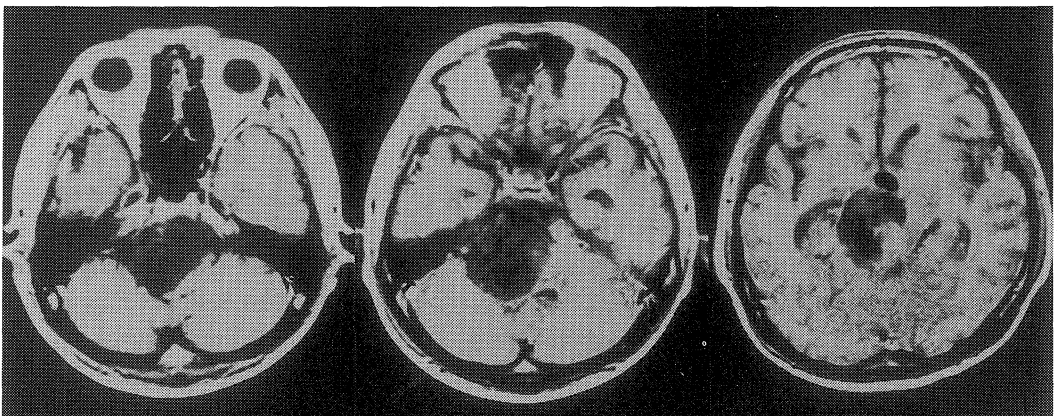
Magnetic resonance imaging (MRI) revealing a hypointensity mass in T1-weighted image located at the left side of the brainstem. The mass extended from the ventral side of the medullae to the left parasellar region and the medial temporal fossa.
